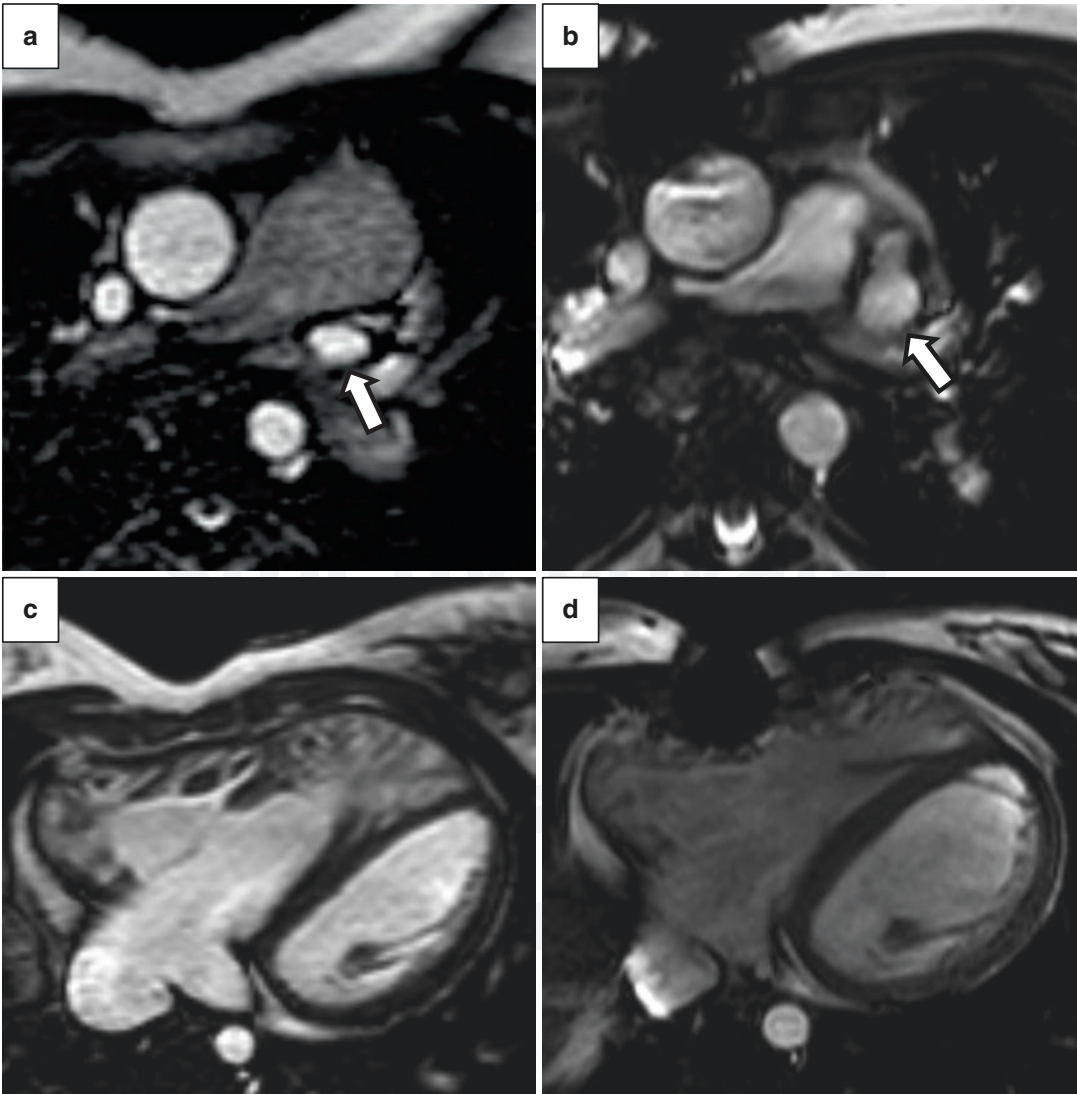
Forty-four-year-old female with corrected TOF. MRI bright blood (SSFP) images of the pulmonary artery and right ventricle before (a, c) and after pulmonary valve replacement (b, d). Dilated pulmonary artery (a) and right ventricular dilatation and hypertrophy (c) before
